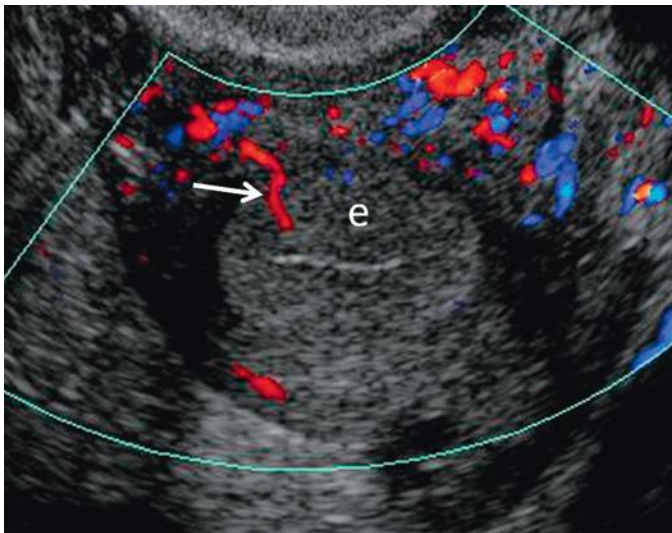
Spiral artery. Transvaginal color Doppler short-axis or transverse view of the uterus demonstrating flow within a spiral artery (*arrow*) within the relatively homogeneous thick echogenic secretory endometrium (e).
